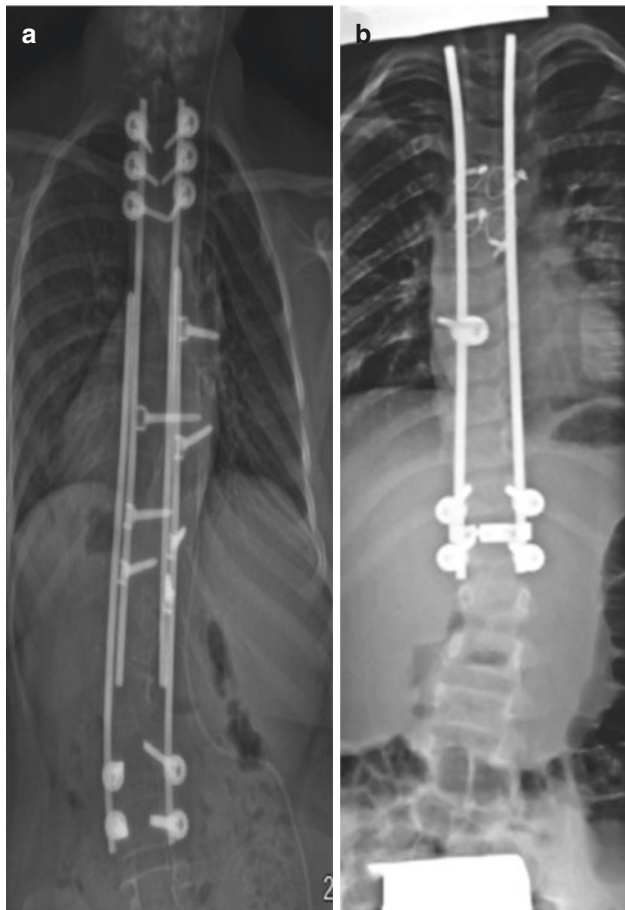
Radiographic differences between two self-growing constructs. For both techniques, a series of gliding spinal anchors maintains the correction by keeping the rods parallel and engaged. As the spine grows, the rigidly proximal-fixed rods will move away from the distally fixed rods. (a) The modern Luqué trolley. (b) An alternative-guided growth construct
